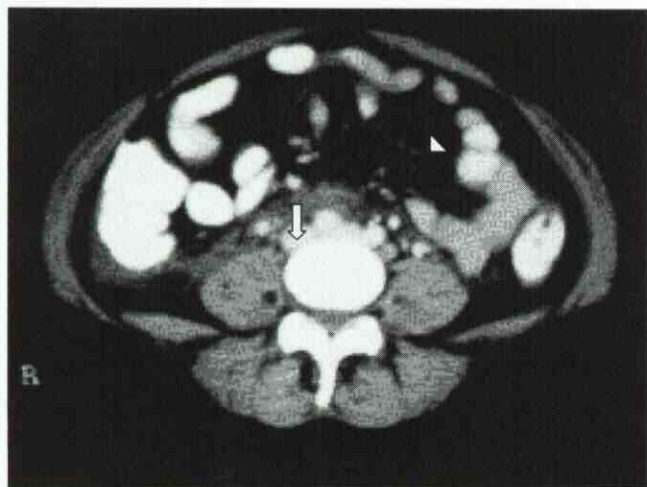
Computed tomography shows a fluid collection (arrow) and inflammatory changes (arrowhead) involving the right paracolic gutter and peri-aortic regions.
